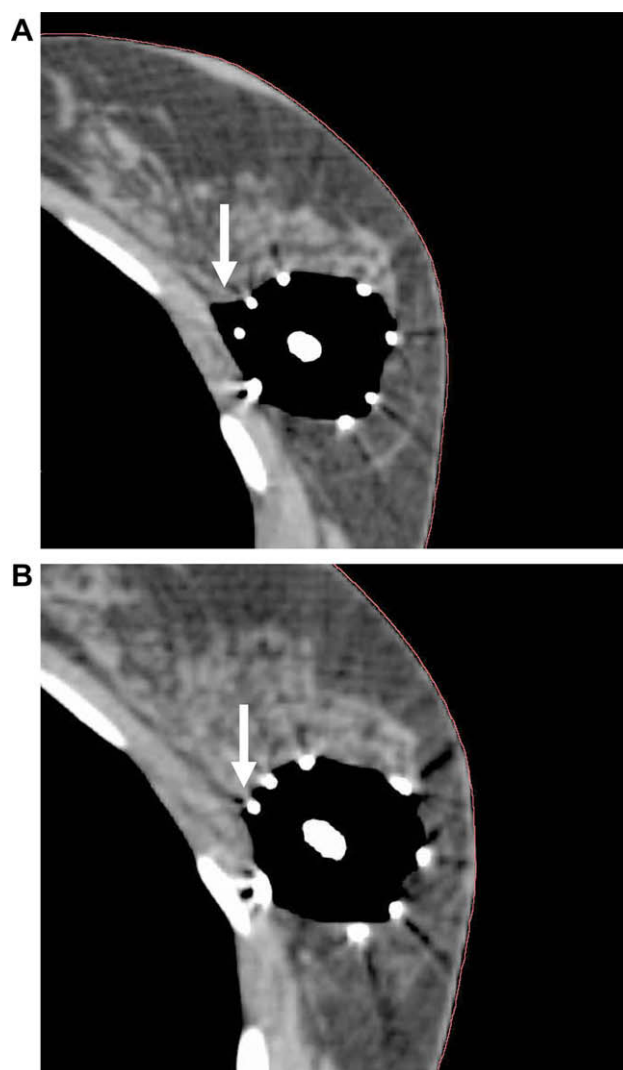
Original CT scan showing a gap between tumor bed and the SAVI struts (A) and a second CT scan showing closure of the gap over a 24-h period (B).
